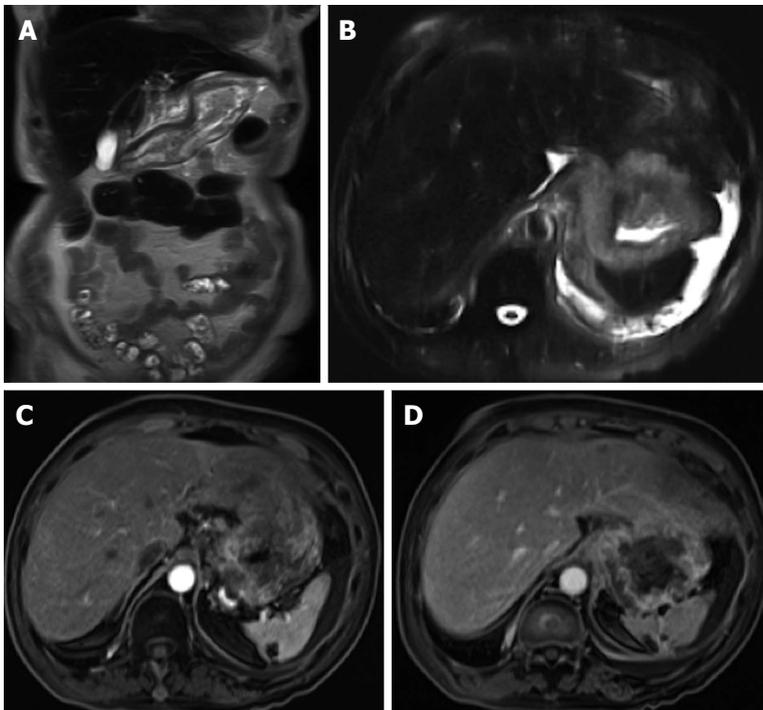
Gastric adenocarcinoma. A: Coronal T2-weighted single shot fast spin echo (SSFSE); B: Axial fat suppressed T2-weighted SSFSE; C: Axial arterial; D: Interstitial post-gadolinium 3D-GRE T1-weighted images. There is diffuse heterogeneous wall thickening of the stomach (A and B) with heterogeneous enhancement (C and D) consistent with linitis plastica. GRE: Gradient recalled echo.
